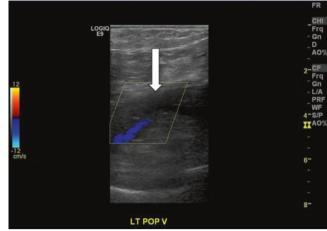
Color Doppler image of the popliteal vein demonstrates echogenic thrombus within the vein (*arrow*). Color flow is demonstrated in the adjacent popliteal artery
